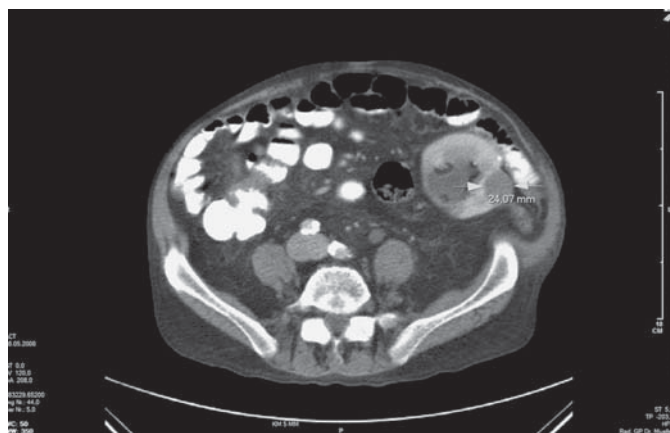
Abdominal CT scan demonstrating a 24-mm rounded, solid upper pole kidney allograft tumor.
